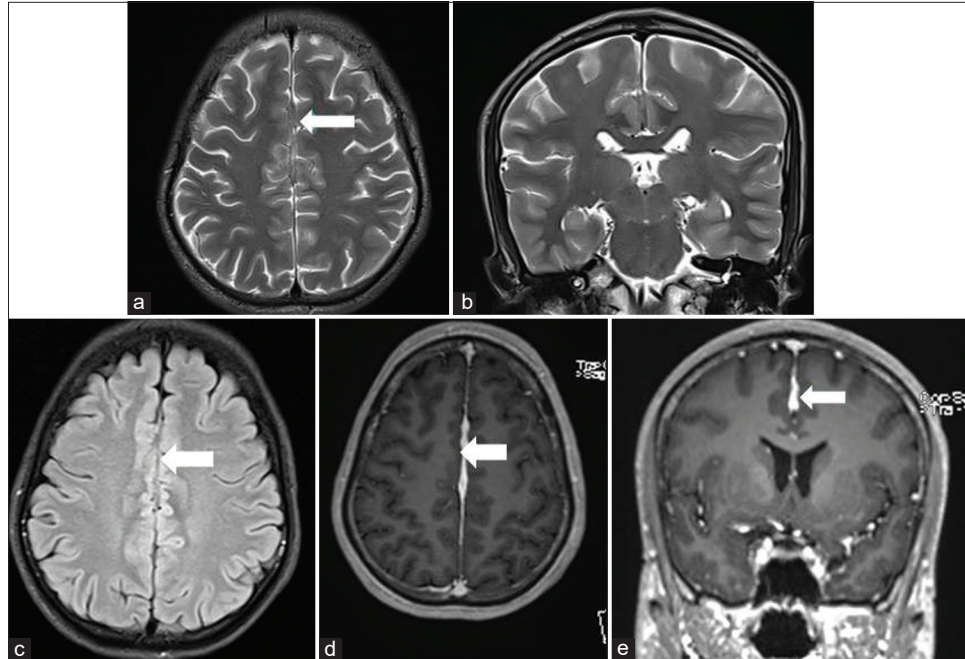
Axial and coronal T2-weighted images (a and b) reveal nodular T2 hypointense decrease in the dimensions of ill-defined lesions in the interhemispheric location. Axial FLAIR image (c) shows an interval decrease in the mild perilesional edema in the cingulate regions. Post-contrast T1-weighted axial and coronal (d and e) images show marked interval reduction in extent and the dimensions of the nodularity in the interhemispheric location.
